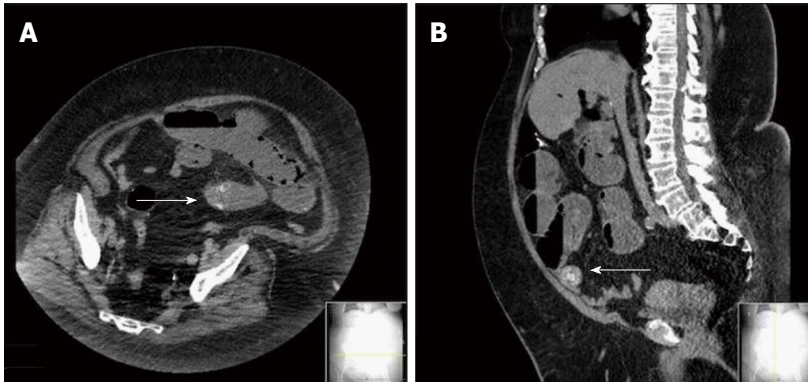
Computed tomography of abdomen pelvis without contrast. A: Axial section demonstrating 31.8 mm gallstone (arrow) in jejunum; B: Sagittal section demonstrating transition point and smaller gallstone (arrow) at proximal ileum.
